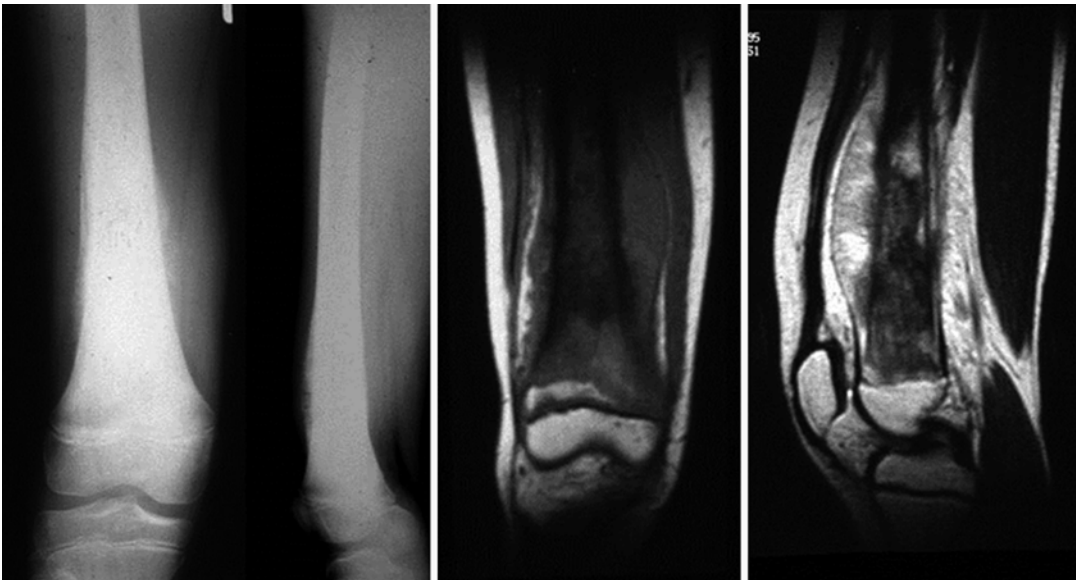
Osteosarcoma of the distal femur. The extent of the lesion and soft tissue component on MRI is much greater than the plain radiographs might suggest
